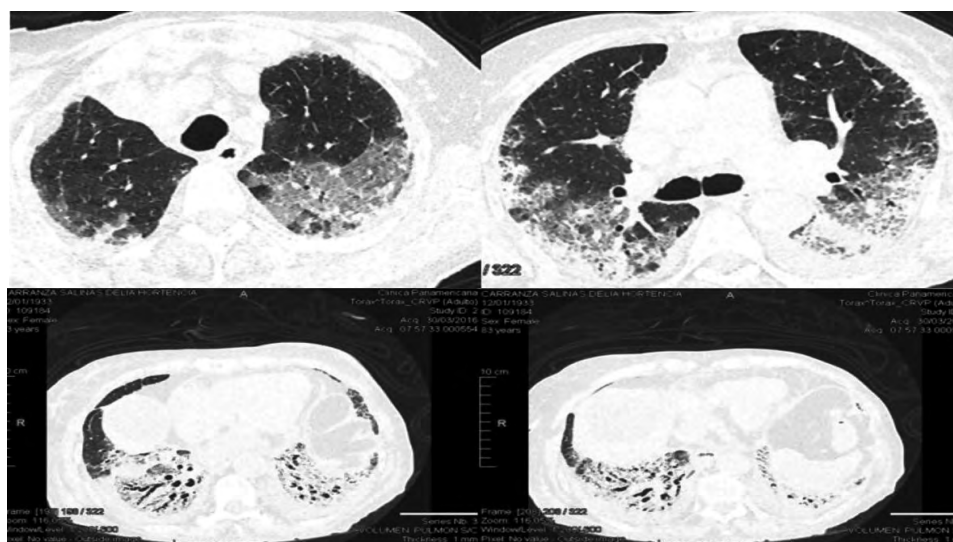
High-resolution computed tomography of the chest on initial presentation. Peripheral ground-glass, traction bronchiectasis. Reticulated opacities were distributed throughout the basal lungs; honeycombing was absent
